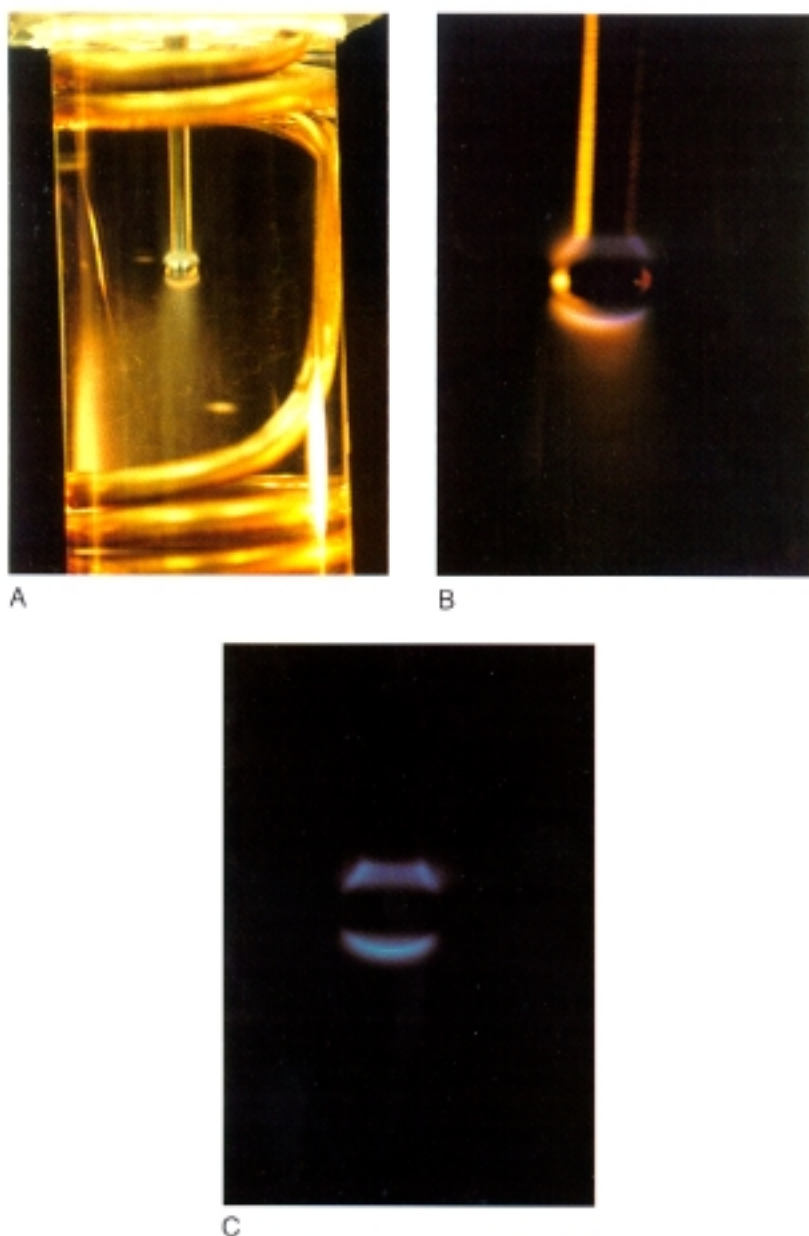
Luminescence from ultrasound assisted lipoplasty (UAL): a dramatic marker for the mechanism of the therapeutic action of ultrasound. *A*, The probe tip oscillating in water with dissolved xenon gas. The copper tubing maintains temperature control. Two types of bubbles can be seen: (1) a beard of bubbles adjacent to the probe surfaces that are most perpendicular to its direction of vibration and (2) bubbles streaming away from the probe tip. *B*, Magnification of the probe showing its beard of bubbles. Taken in dim light, this provides an outline of the tip location. *C*, A 1-minute exposure with no external lighting, showing the sonoluminescence from the 5 mm UAL tip (Mentor) driven at 75% front panel setting power. The water in which the tip is immersed is maintained at 11°C and the naturally dissolved air has been removed and replaced with xenon at approximately 50% saturation. Light originates from a sheath of bubbles that form at the pressure maxima of the dipole sound field set up by the probe. The authors propose that the stress field and heating focused by these bubbles account for the therapeutic action of UAL.
